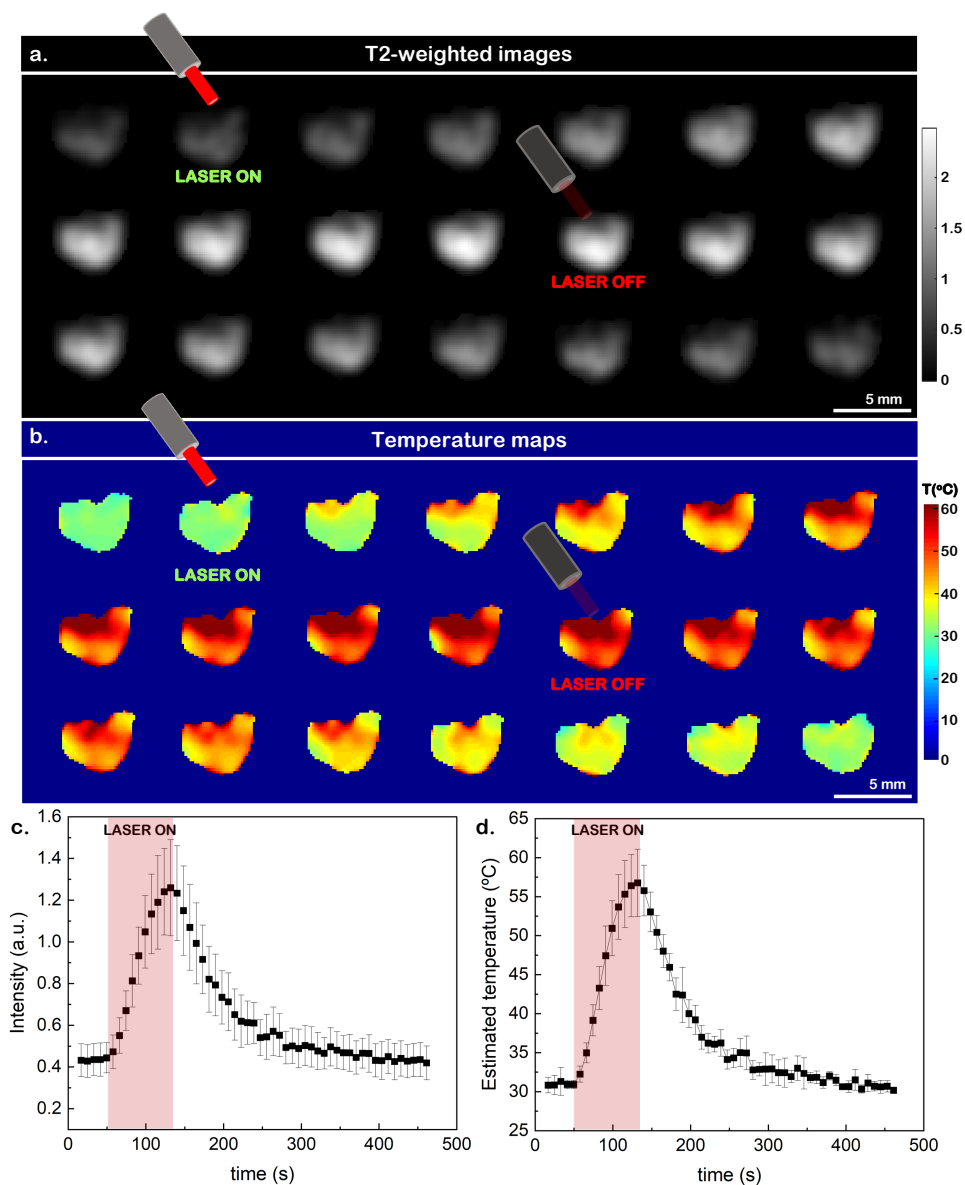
(a) T₂-weighted images obtained with a cell sample ($150 \mu\text{g mL}^{-1}$ incubation concentration of Fe₃Se₄ NPs) before, under NIR irradiation for 82 s at 0.67 W cm^{-2} , and after that irradiation (8 s integration time per image, pixel size of 0.16 mm); (b) Associated temperature maps determined through the obtained calibrations; (c) Variation with time of the average MRI intensity and (d) variation with time of the average temperature estimated from the intensity images (data presented as average value \pm s.d.). Please see the SI Videos with the temporal evolution of the MR images and temperature maps.
